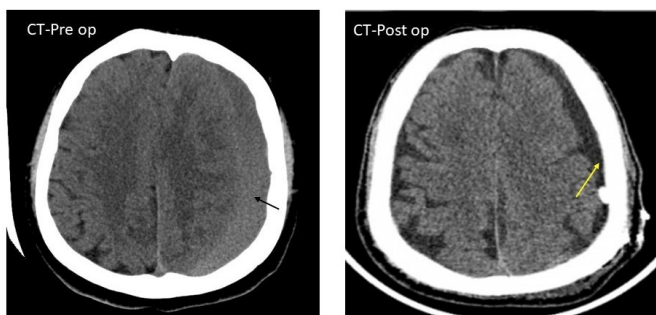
Non-contrast pre and post-op CT scan head of a 55/male patient with homogenous, iso-dense chronic subdural collection significant mass effect (black arrow). Note the reduction of chronic subdural hematoma collection in the post-op scan (yellow arrow). This patient underwent a single parietal burr hole with closed system drainage.
